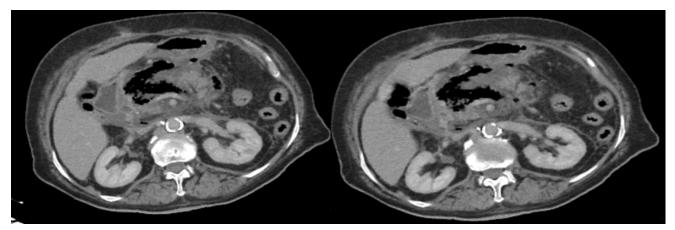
Abdominal CT showed dirty appearance and freefluid in peripancreatic localization in and around choledochus, hypodense air values around the pancreas and heterogeneous density areas.
